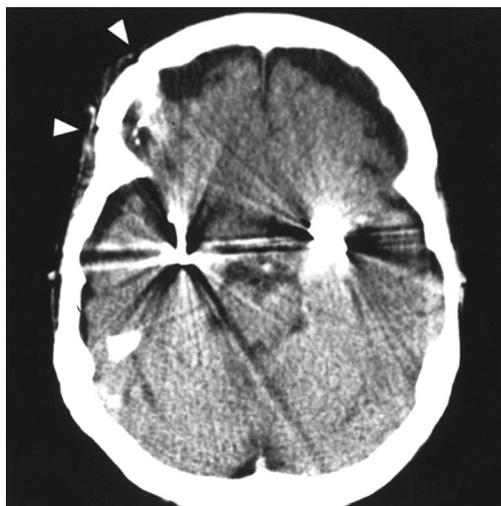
Postoperative CT scan revealing bifrontal hygromas without a space-occupying effect. Note the extension of the right-sided limited supraorbital craniotomy (arrowheads) and the position of both aneurysm clips.
